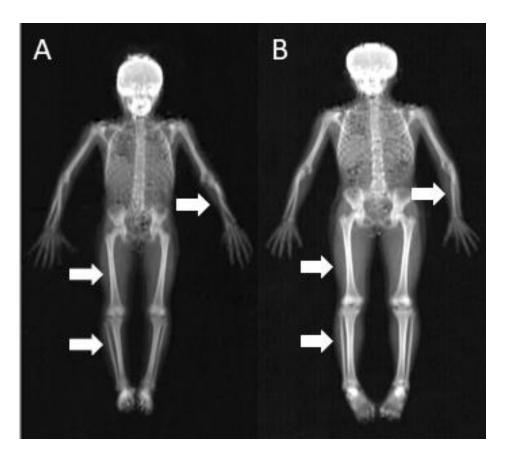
Whole body dual-energy X-ray Absorptiometry (DXA) scan for a 9.4 year old child with cerebral palsy (A; CP) at GMFCS level II, and a typically developing child (B; Con) with the same age, sex and race. The white arrows point to the soft tissue, a combination of fat mass and fat free soft tissue at the appendicular regions. Children with CP have much less soft tissue compared to Con.
